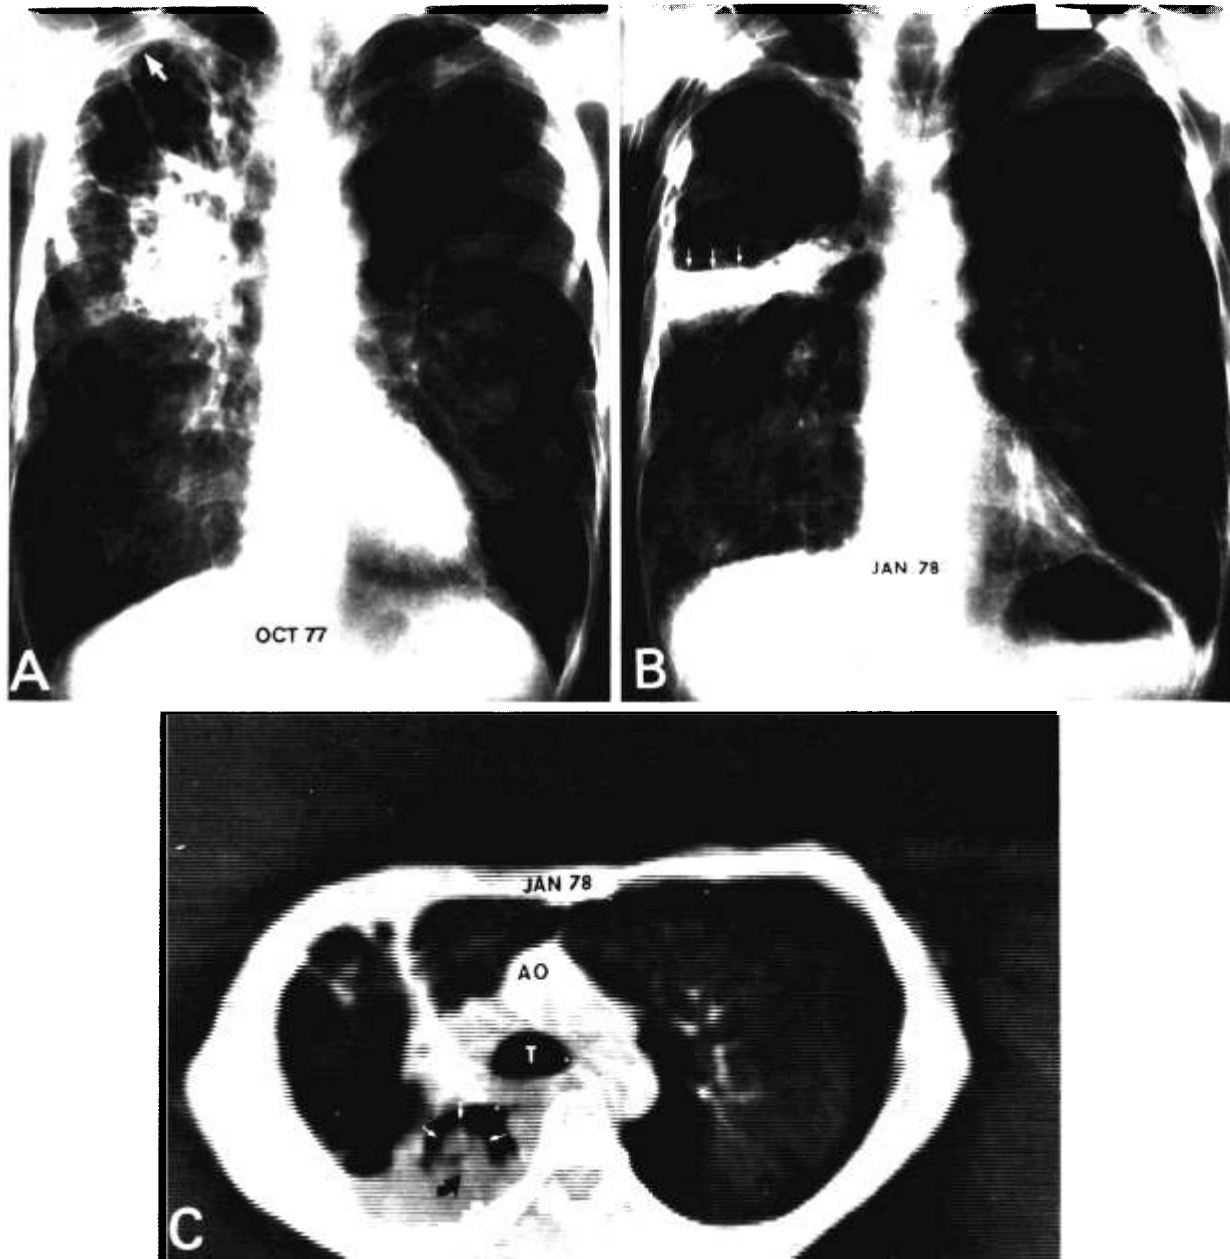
A. Case 2—PA Chest Roentgenogram (October 1977). An infiltrate with varying sized cystic spaces is present in the right upper lobe. Minimal pleural thickening is evident laterally (arrow). B. PA Chest Roentgenogram (January 1978). A large cavity containing an air-fluid level (arrows) now occupies the right upper lung zone. Progressive pleural thickening is evident laterally. No mycetoma is evident. C. 2½ Minute Supine CT Scan (January 1978). Posteriorly in the right upper lobe an intracavitary mass (black arrow) is capped by air anteriorly and laterally (white arrows). A prone scan confirmed the mobility of this mycetoma. The mycetoma was not visible on standard tomograms. AO = aortic arch. T = tracheal lumen.
